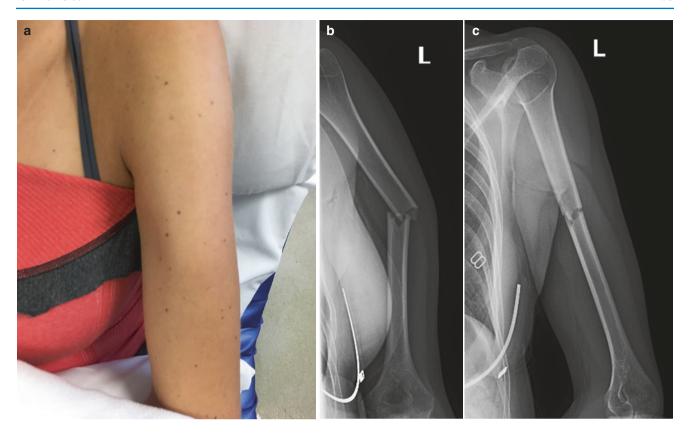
Clinical (a) and radiograph (b, c) images of a 19 year-old female who sustained a humeral shaft fracture with deformity after a fall while skiing
